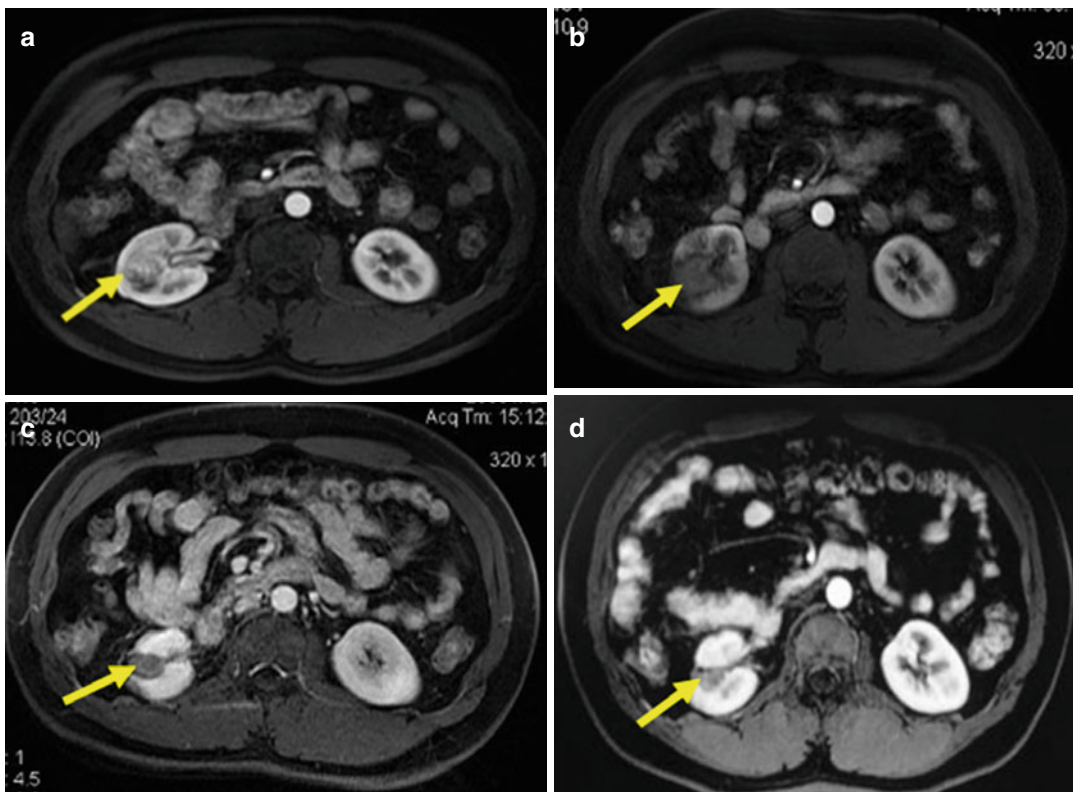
MWA in a 45-year-old man with right RCC adjacent to the renal pelvis. (a) Preablation arterial phase magnetic resonance imaging (MRI) scan shows one heterogeneous enhancement of neoplasm (arrow) near the renal pelvis with the size of 2.4×1.9 cm. (b) Arterial phase MRI scan obtained 2 months after ablation shows
